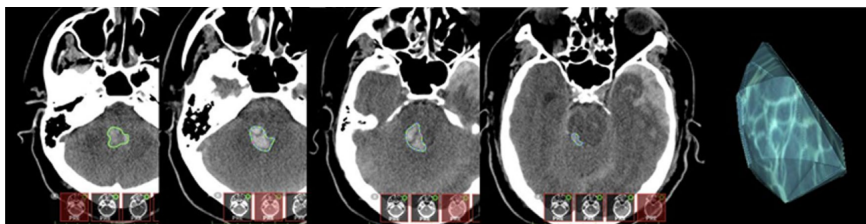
Brainstem lesion segmentation on ascending axial head CT. Borders (light green) are hand-traced through the slices in OsiriX MD software. These demarcated areas are merged to create a 3D region of interest for further quantitative analysis (last image on the right). Taken from William et al. [19].*
